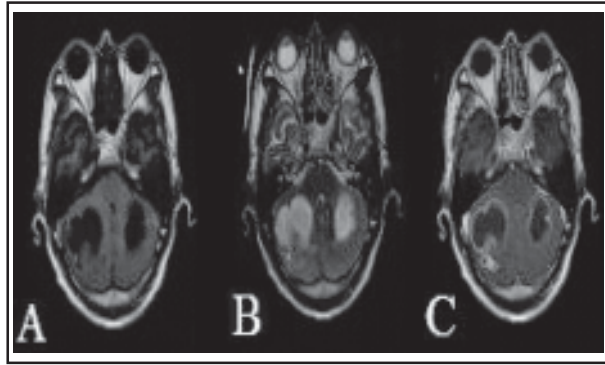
MRI scan of the cranial: T1 (A), T2 (B) and enhancement (C).
